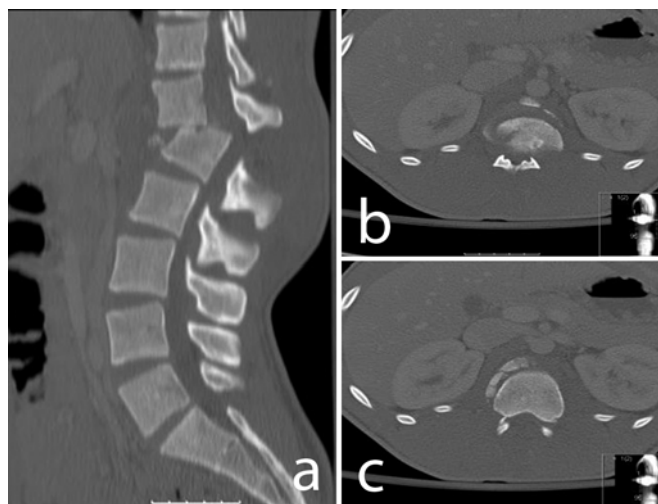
Imaging of 21-year-old male patient demonstrating an L1 burst fracture on both CT and MRI with vertebral body fragmentation and retropulsion into the spinal canal.
